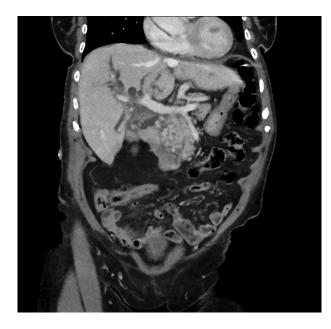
Computed tomography abdomen coronal view reflecting numerous calculi in the common bile duct.
